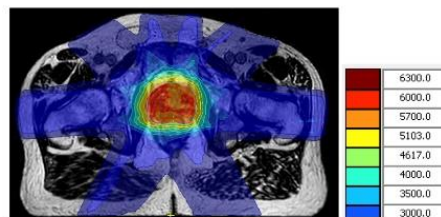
Example of a new daily online MR plan, 7-field IMRT prostate radiotherapy. This is created by adapting a CT-based reference plan, using the anatomy of the day. Red line- Prostate CTV.
